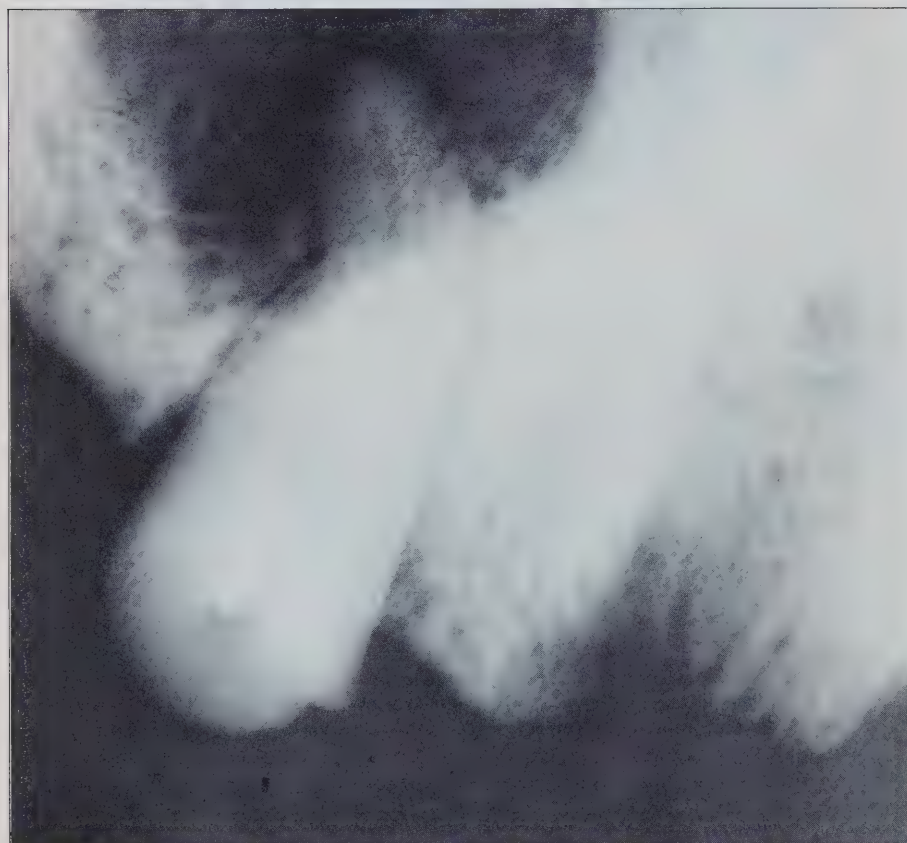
Radiograph of right lateral maxillary incisor of a Nabatean skull (circa 200 B.C.) showing a bronze wire, approximately 2.5 mm long inserted into the root canal. Note the dilacerated root and periapical abscess. Same tooth as Figure 6. (By kind permission of J. Zias).
